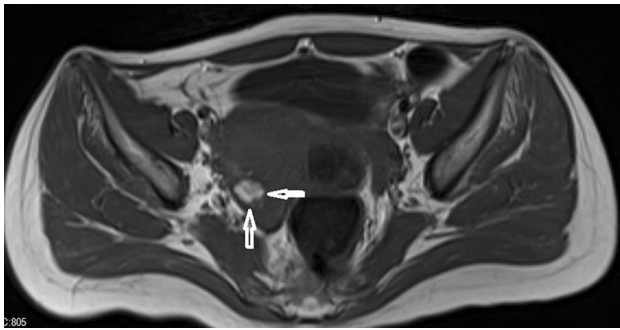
T1-weighted axial pelvic MRI showing (arrows) right ovarian cystic teratoma
